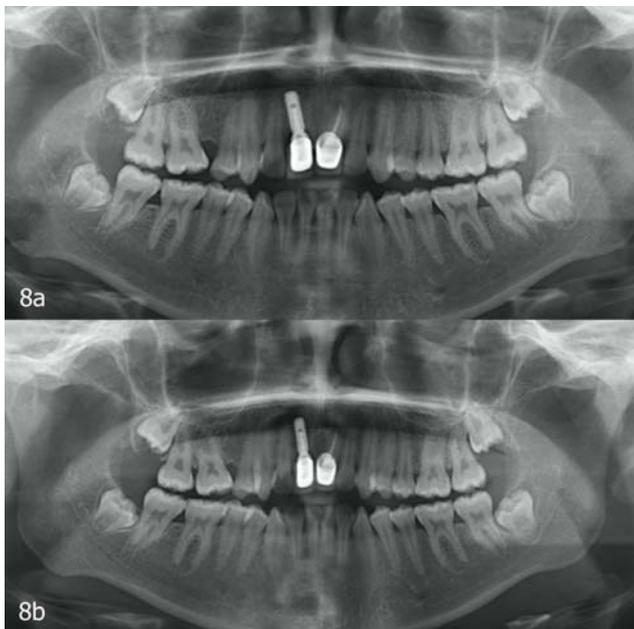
a: Radiographic appearance 15 months after the treatment.
